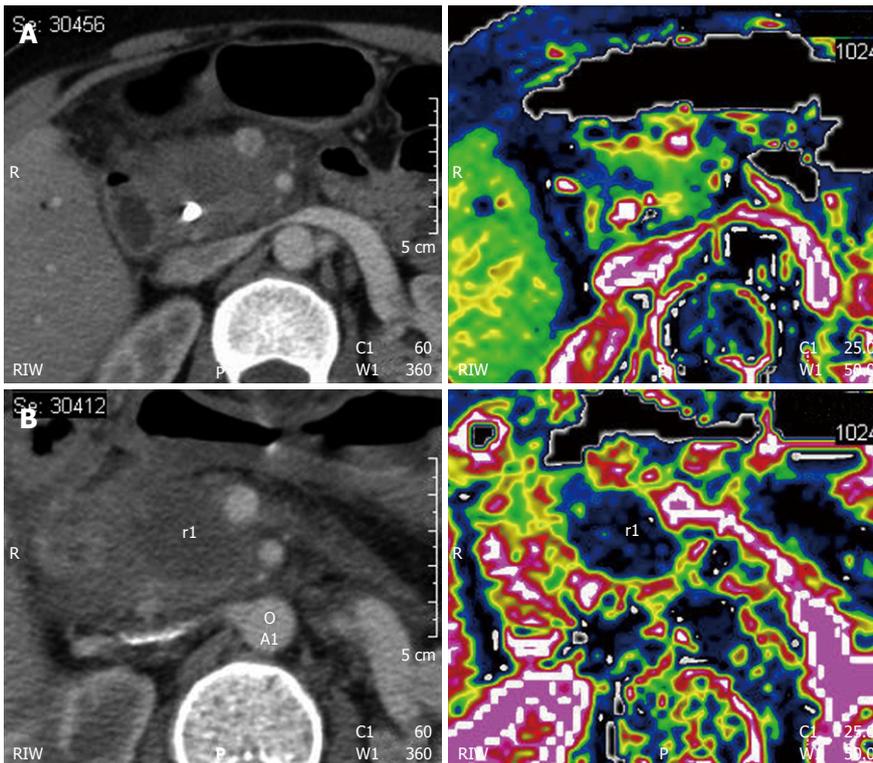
Pancreatic ductal adenocarcinoma before and after radiofrequency ablation. A: Contrast-enhanced computed tomography (CT) of pancreatic head lesion that appears hypodense and vascularized at perfusion CT (right side); B: Contrast-enhanced CT of the lesion after radiofrequency ablation, which appears hypodense and avascular at perfusion CT (right side).
